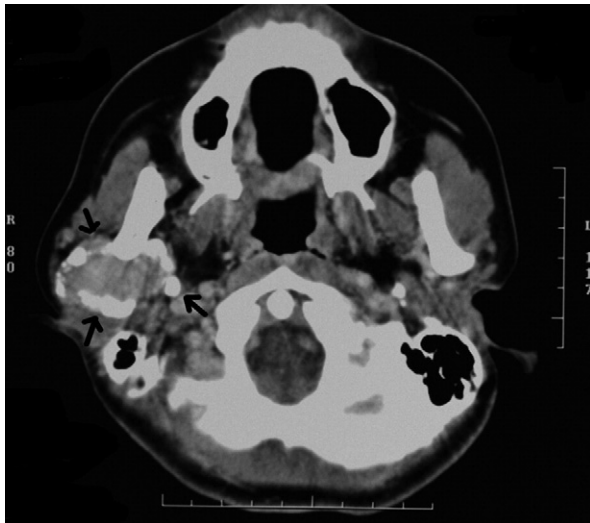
Axial computed tomography reveals a focal soft-tissue enhancing tumor near and inferior to the right temporomandibular joint (arrows). Extensive ossification or calcification is seen in the periphery of this lesion.
